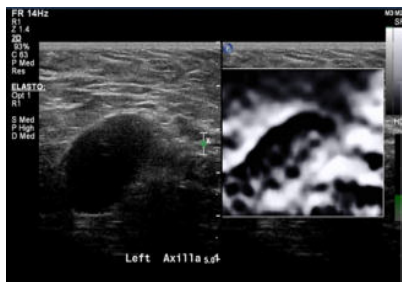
Suspicious lymph nodes on Axillary ultrasound
